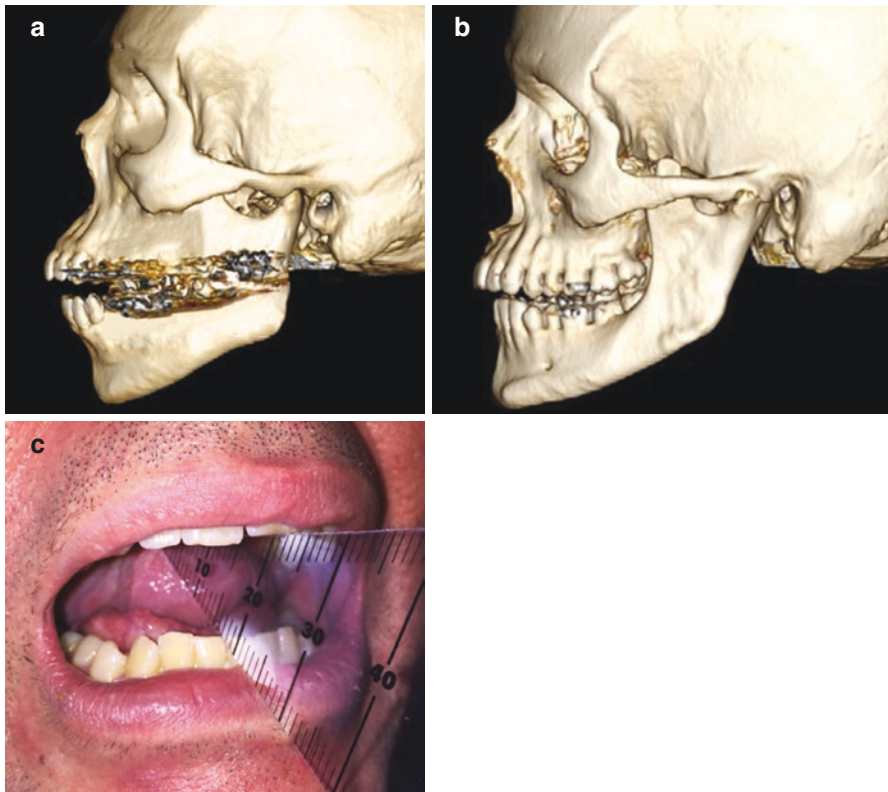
(a) Three-dimensional CT scan reconstruction showing normal temporomandibular joint and coronoid process. (b) Three-dimensional CT scan reconstruction showing coronoid process hyperplasia of the mandible and ankylosis of the temporomandibular joint. (c) Photograph of patient depicted in Fig. 2.2b showing restricted mouth opening of 17 mm
